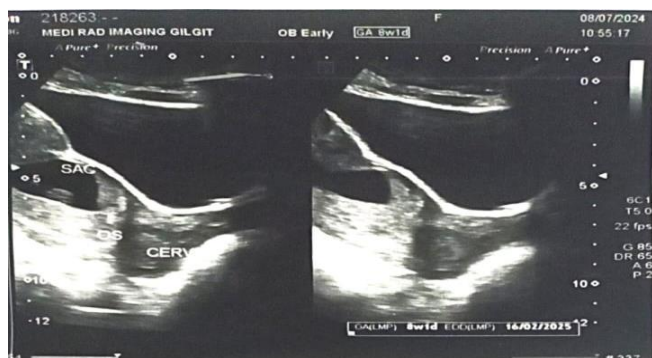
Ultrasound results of Caesarean Scar Ectopic Pregnancy Case.
